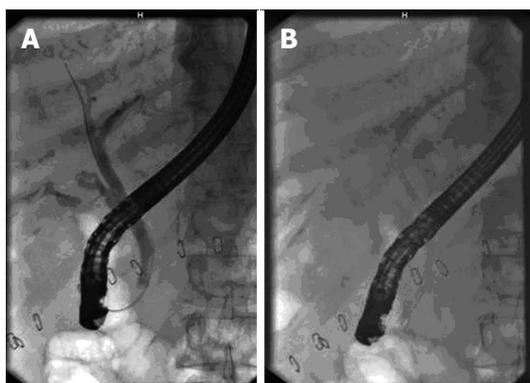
Radiograph at endoscopic retrograde cholangiography. A: Radiograph at endoscopic retrograde cholangiography showing biliary leakage into peritoneum from cystic duct stump; B: Radiograph showing 10 F biliary stent inserted above the level of the leak from cystic duct stump.
